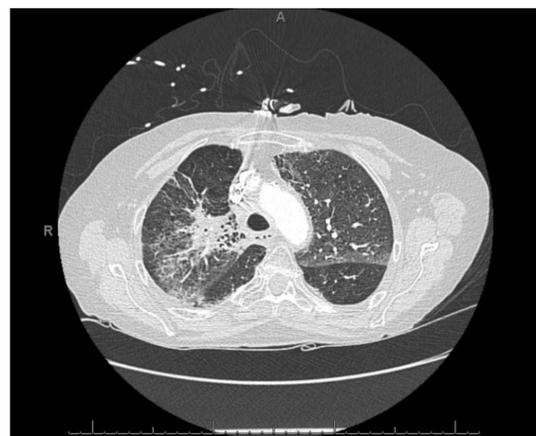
CT-PE from OSH was negative for PE. Lungs showed diffuse prominence of bronchovascular and interstitial markings, ground glass densities and atelectasis bilaterally, most significantly in the R upper lobe. No lobar consolidation or lymphadenopathy was present.
